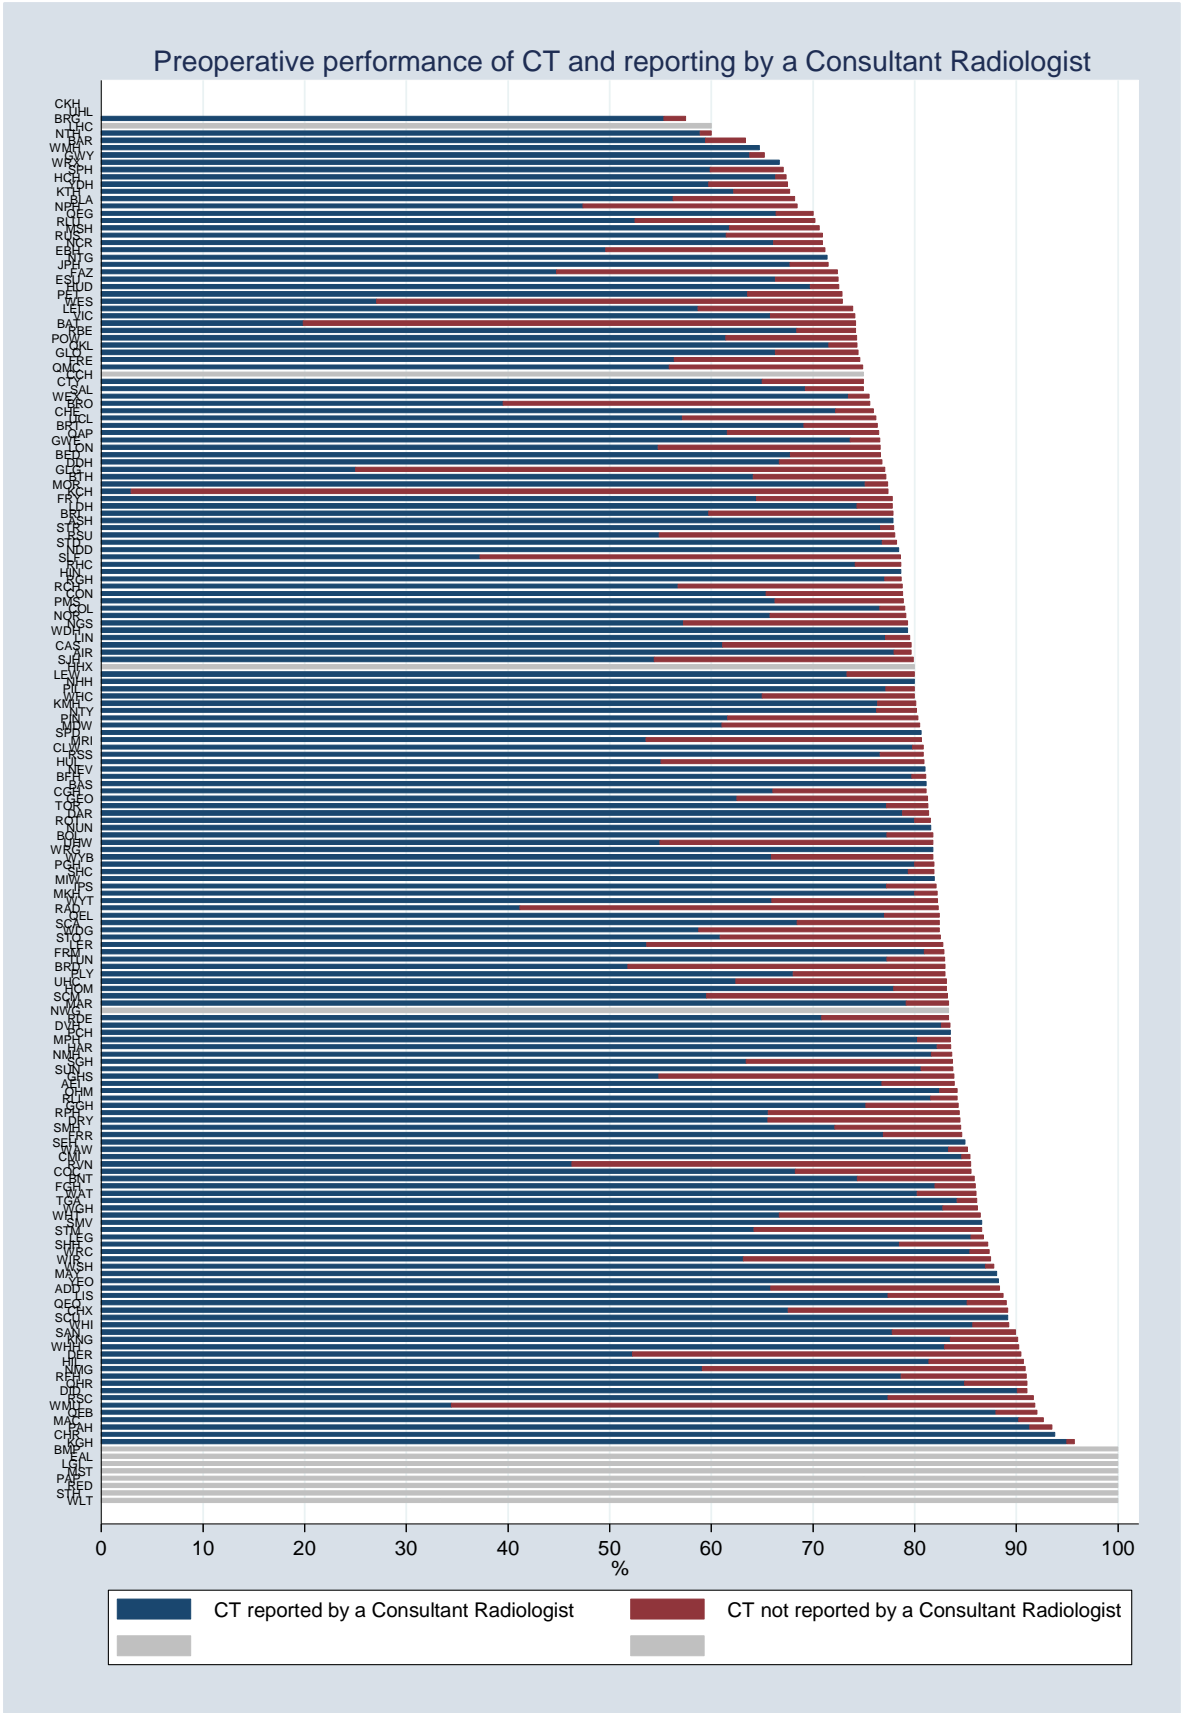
CT scanning and reporting by a consultant radiologist before emergency laparotomy. (Grey bars indicate hospitals submitting fewer than ten cases)
